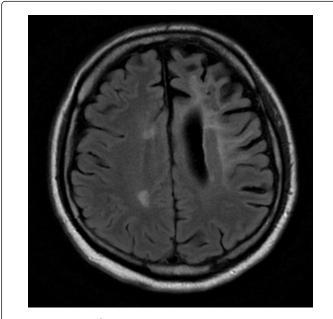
MRI (22nd May 2015).
